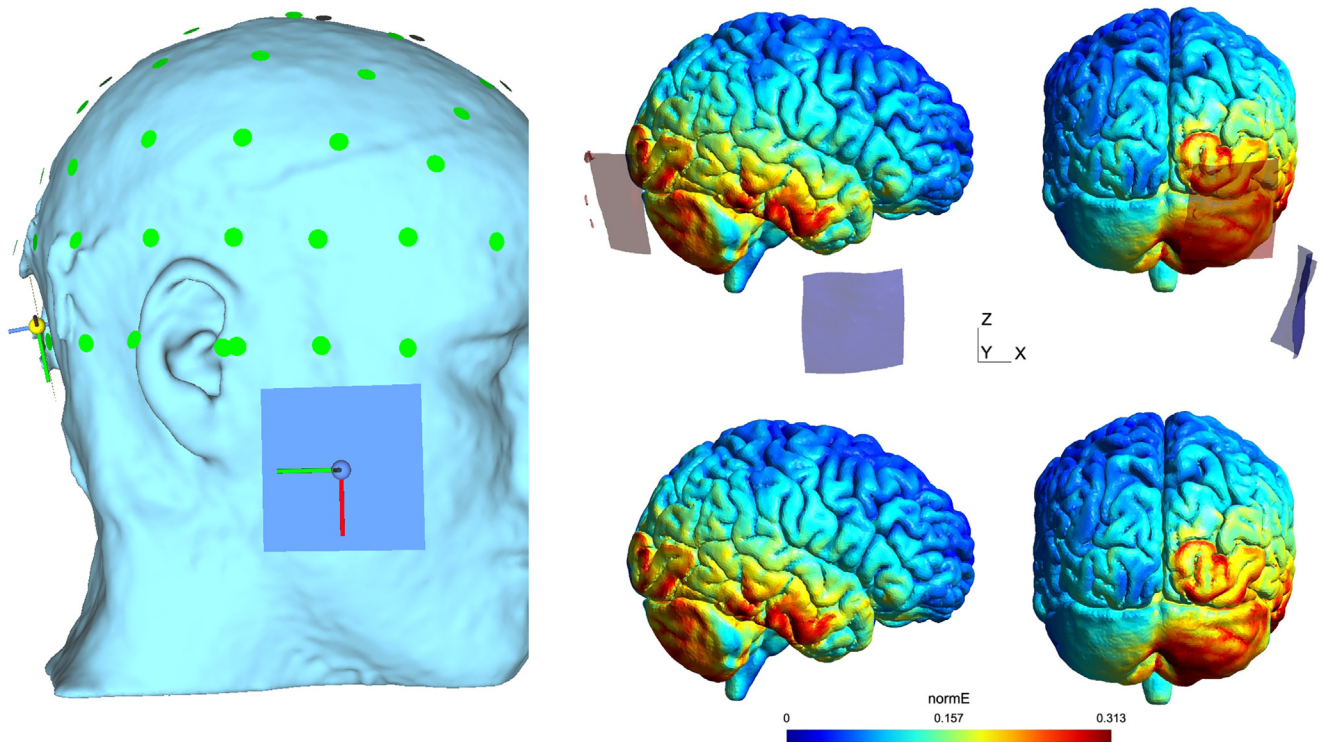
Electrode montage used for electric field modeling in SimNIBS. Active electrode (anode) was positioned based on individual participant MRI scans and the return electrode (cathode) was positioned over the right jaw bone to approximate the right clavicle.
